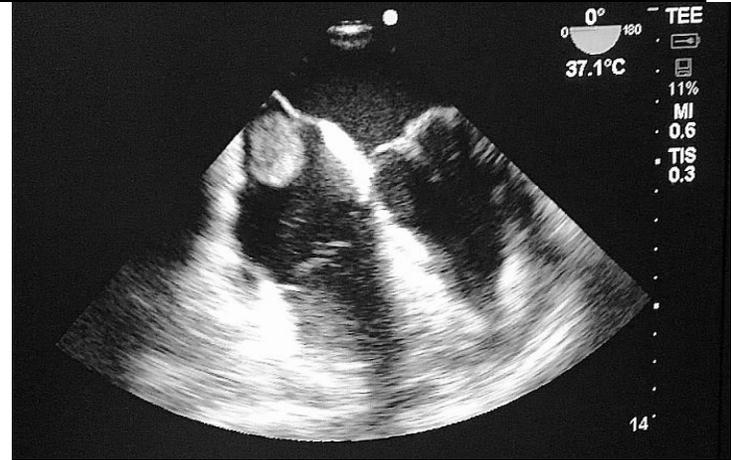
2-chamber view of the heart with intraoperative trans esophageal echocardiography (TEE)
